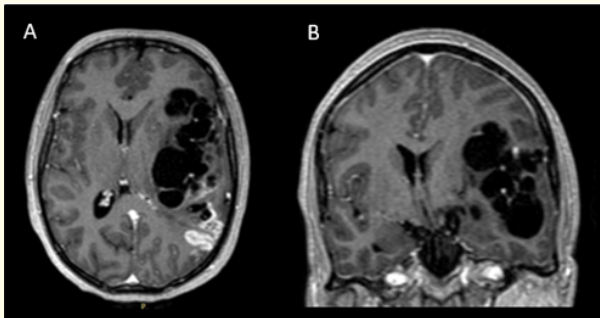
Contrast MRI. A: Axial view; B: Coronal view.
